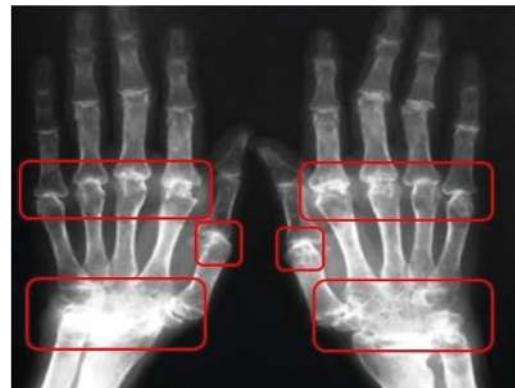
Radiographic changes in late RA—note the joint erosions and damage of the articular surface of several metacarpophalangeal joints; advanced damage, destruction, subluxation and ankylosis of the wrist joints (shown as red boxes)
